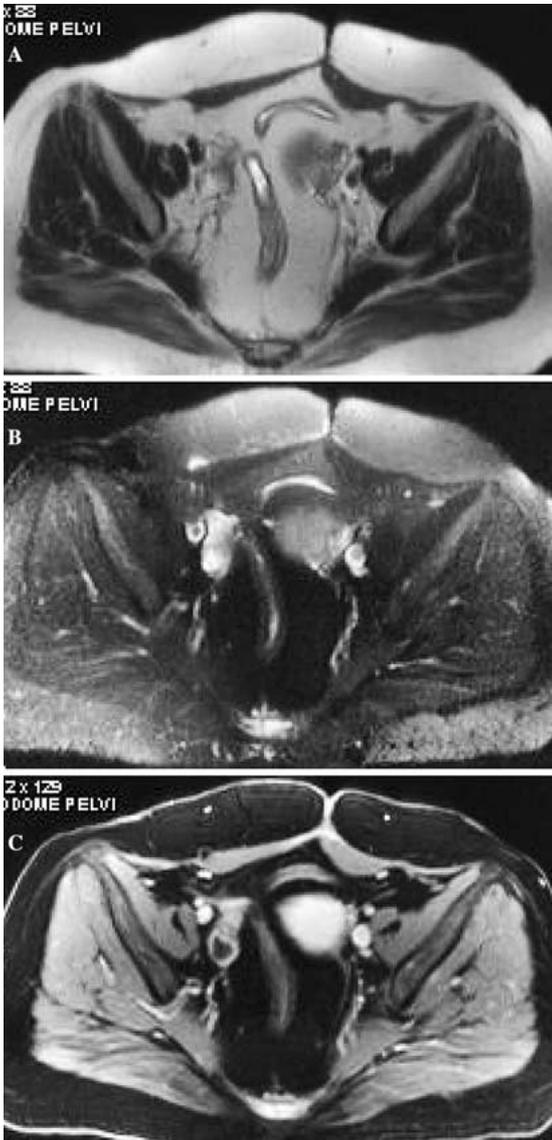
Inactive sigmoid colon and rectum in a 45-year-old female with longstanding UC. A Axial T2-weighted half-Fourier single-shot turbo spin-echo image shows complete loss of haustration at the level of the sigmoid colon, with minimal wall thickening and a large amount of surrounding fibrofatty proliferation. B Axial T2-weighted half-Fourier single-shot turbo spin-echo fat-suppressed image displays complete darkening of the sigmoid colon wall, suggesting inactive disease. C Axial T1-weighted fat-suppressed gadolinium-enhanced fast low-angle single-shot image demonstrates lack of wall enhancement at the level of the sigmoid colon, thus confirming inactive disease.
